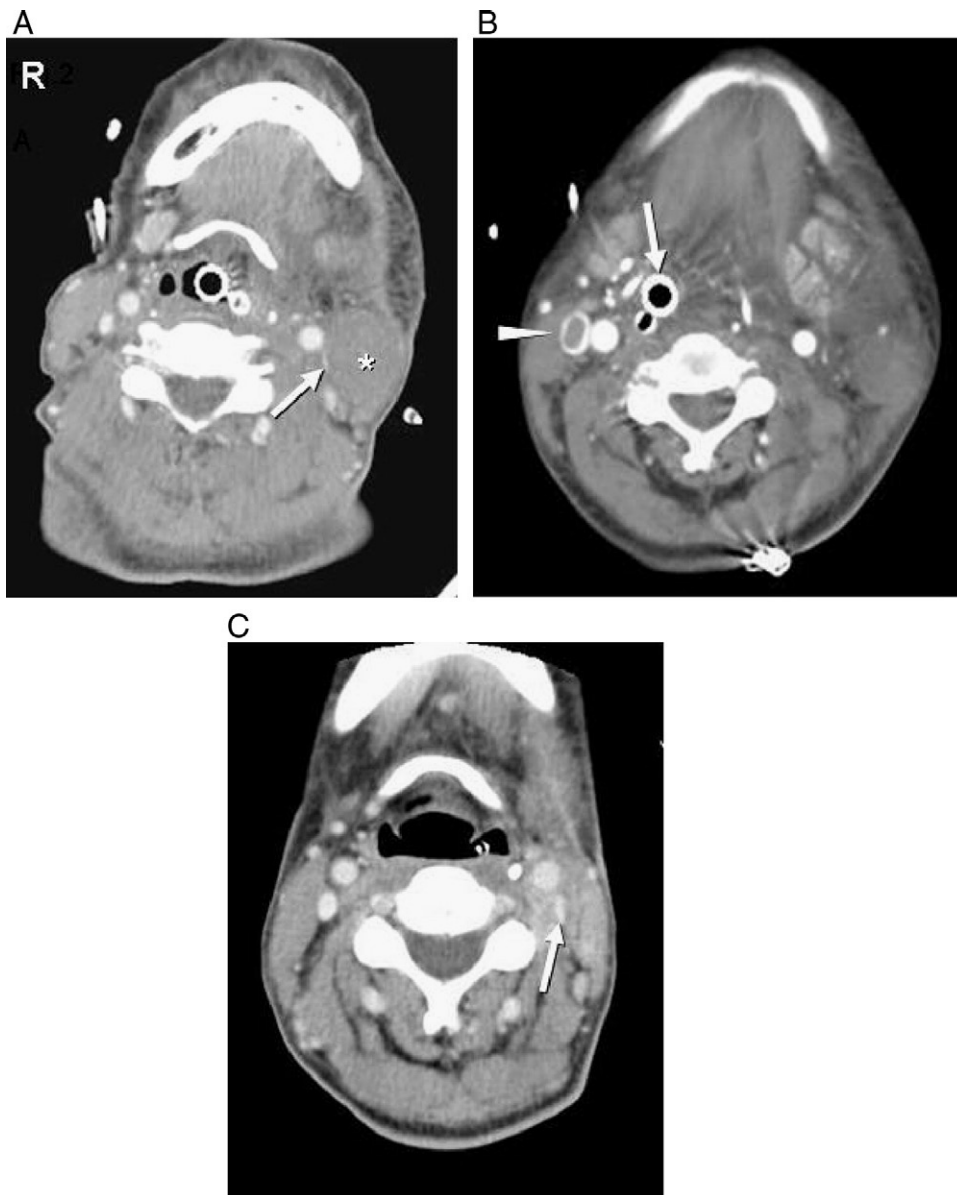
Consecutive postoperative contrast-enhanced computed tomographs of the neck. A: At 2 hours after surgery, there is neck swelling on the left because of swelling of the muscles and deep soft tissue. The left internal jugular vein is markedly compressed (arrow) by the swollen sternocleidomastoid muscle (asterisk). A central venous catheter inserted in the right internal jugular vein is also seen. B: Progressive swelling at 1 day after surgery. There is marked displacement of the trachea toward the right (arrow). Note thrombus formation in the right internal jugular vein (arrowhead). C: By the 20th postoperative day, there is almost complete resolution of the swelling. The internal jugular vein is normalized; its caliber on the left is normal (arrow), and the thrombus on the right has disappeared.
